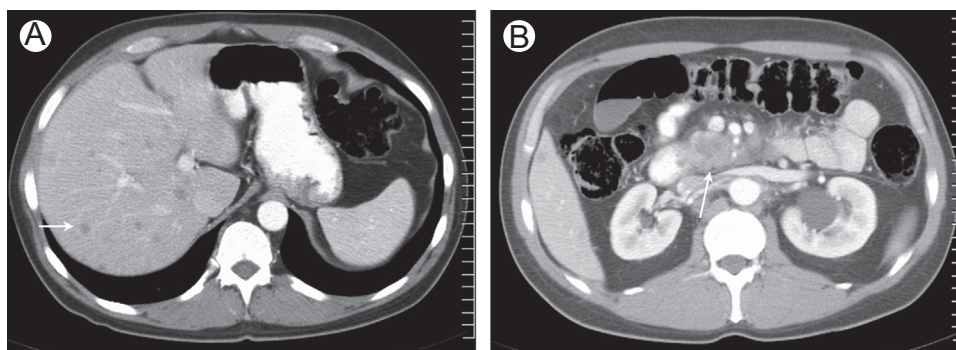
Multiple hypodense metastatic foci (arrow, A) on a portal venous phase CT in a patient with a pancreatic uncinate process mass (arrow, B).
